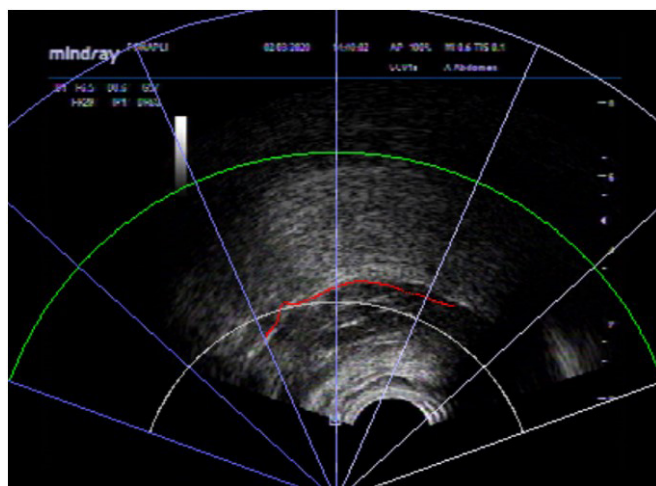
Tracing of the neotongue surface in the anterior and posterior part with the use of tongue ultrasound biofeedback.
